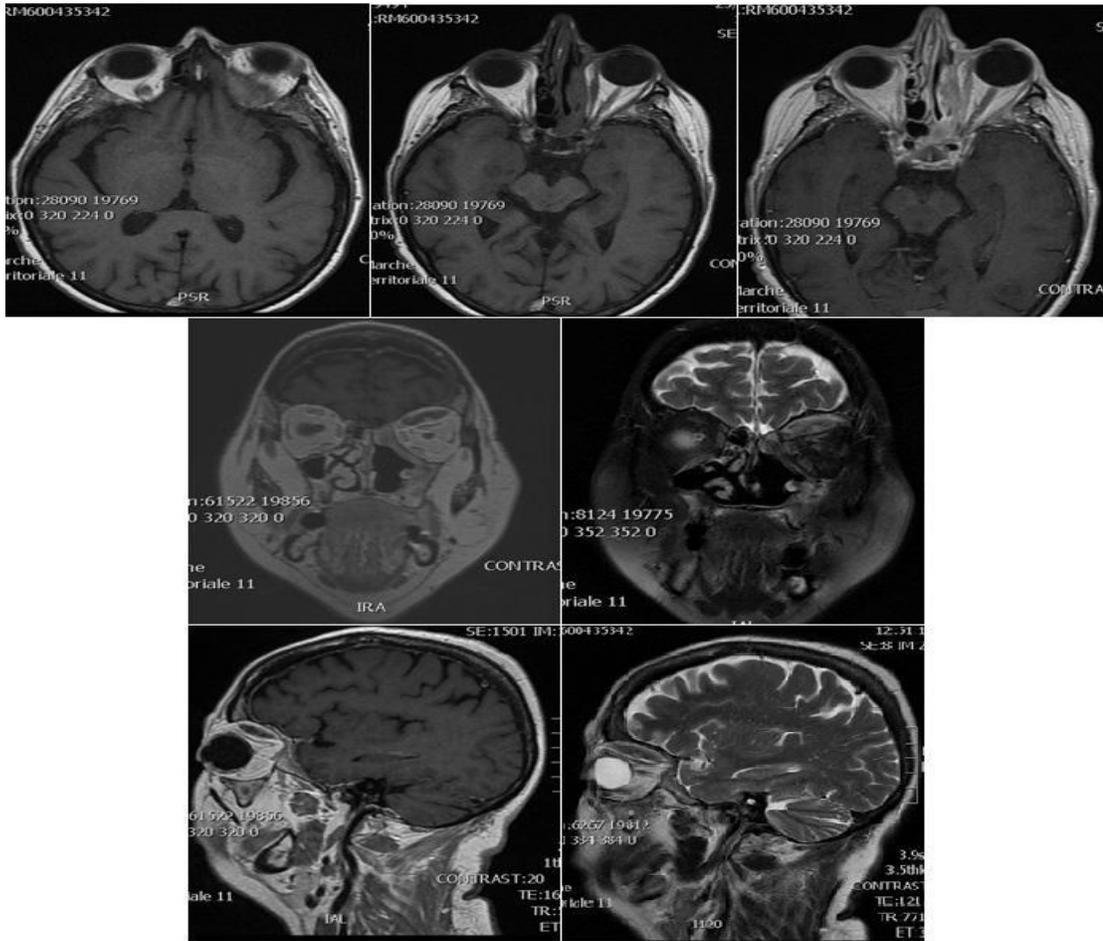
MRI: Dural enhancement.
